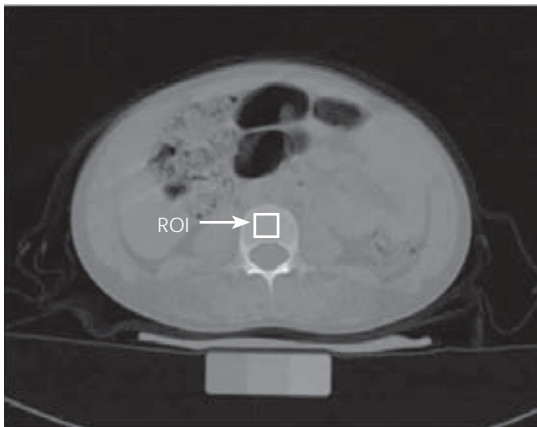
CT axial image of L3 vertebra with a ROI identification in the trabecular bone.
